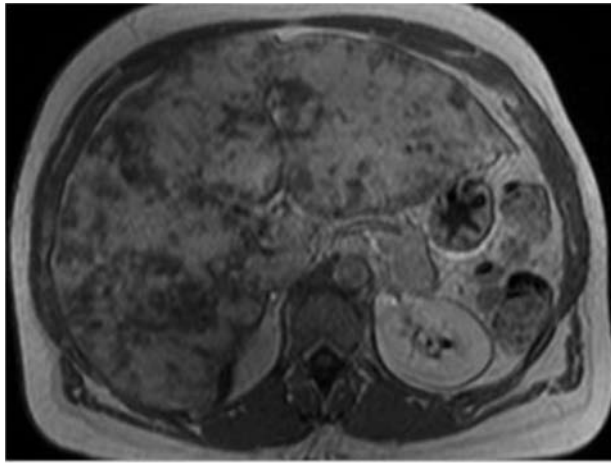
Abdominal magnetic resonance imaging in November 2005 (T1 with gadolinium injection) showing hepatomegaly related to hypervascular tumoral infiltration of the liver.
